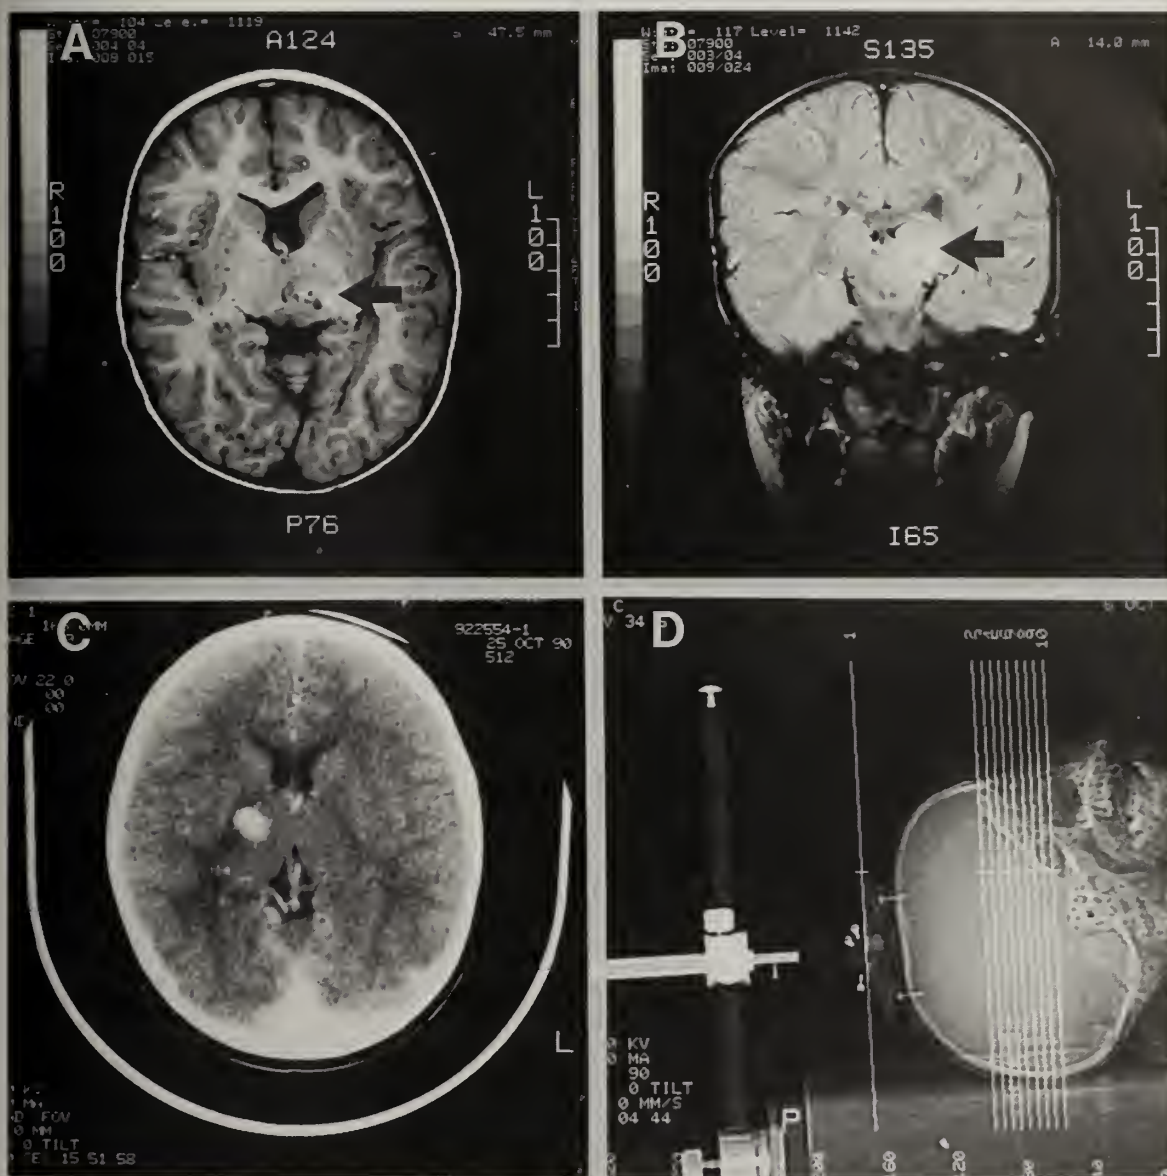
Representative MRI or CT scans of patients who underwent stereotactic biopsy. Panel A: T1 weighted, axial view of lesion (arrow) in region of left thalamus, indicating the sensitivity of MRI for detecting small lesions. Panel B: Coronal view of same patient. Panel C: Contrast-enhanced CT scan of 1 cm lesion involving the right internal capsule (different patient). Stereotactic biopsy showed both of these lesions to be low grade astrocytomas. Panel D: Scout film, demonstrating sections obtained through the skull mount and target area.
